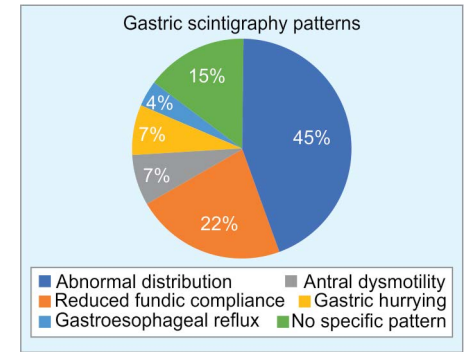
Baseline scintigraphy pattern observed in the 27 patients
